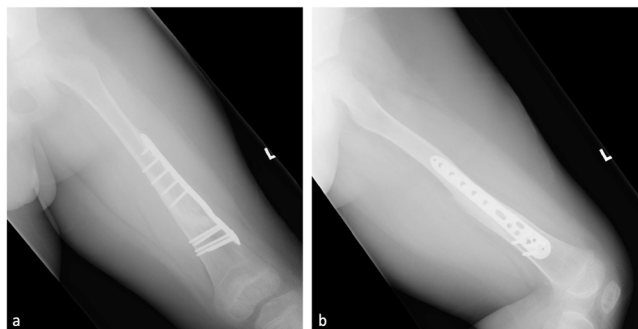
(a,b) Plain radiographs taken nine months post-surgery show complete union and good remodelling with no signs of local recurrence.
